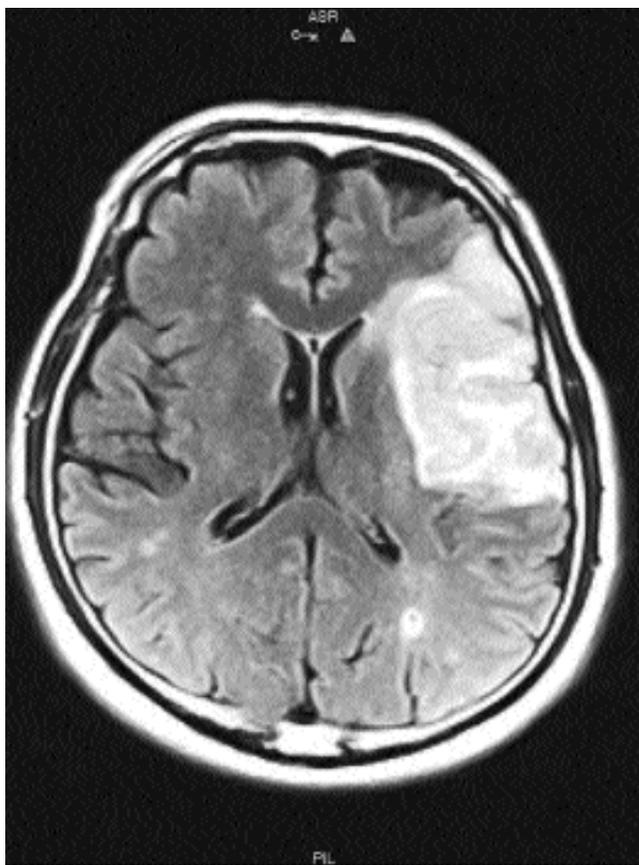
Magnetic resonance imaging (MRI) of brain showing a left middle cerebral artery territory infarct.
